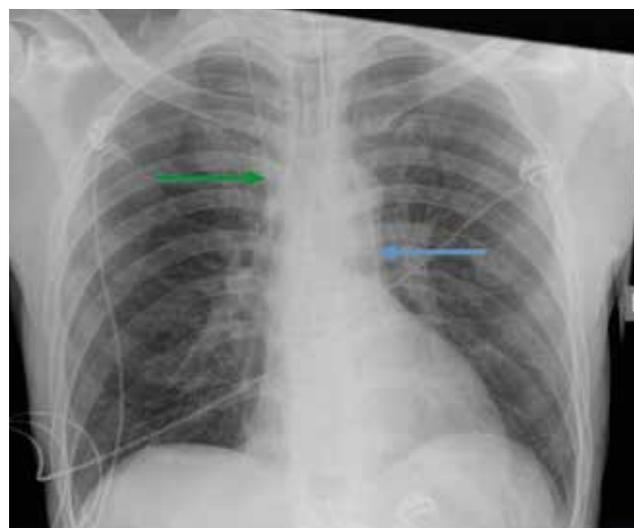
AP chest X-ray: two CVCs are visible, the blue arrow indicates the first CVC with malposition left parasternally over the heart, the green arrow indicates the second CVC with its tip projecting over the superior vena cava.
